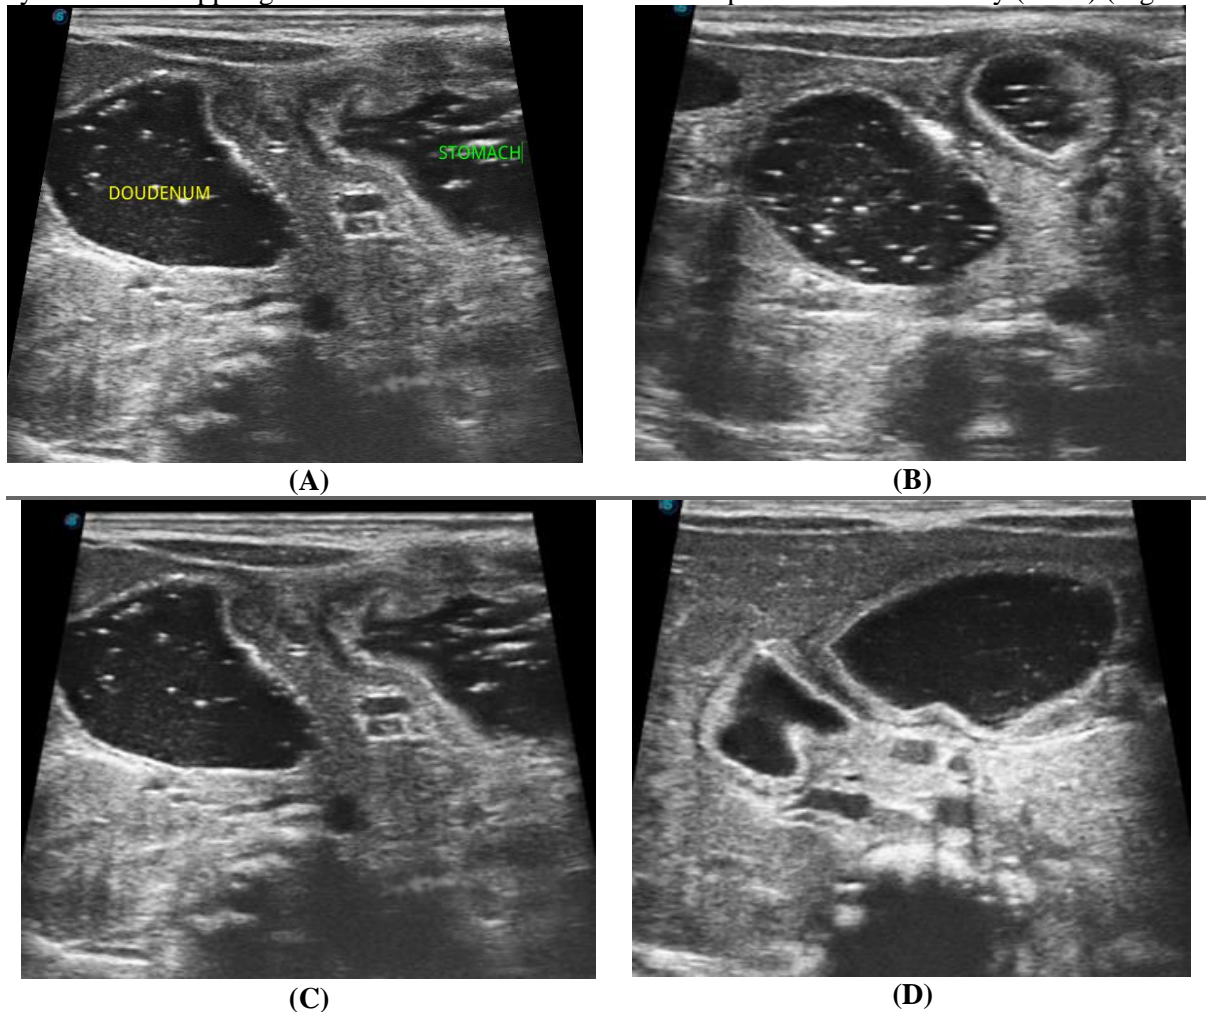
Ultrasonographic images of the GI tract after saline intake in neonates with AP showing dilated stomach and dilated proximal duodenum with collapsed distal part (A) on serial scanning after 5, 10, and 15 minutes (B, C and D) persistent dilatation is noted suspecting obstruction.
